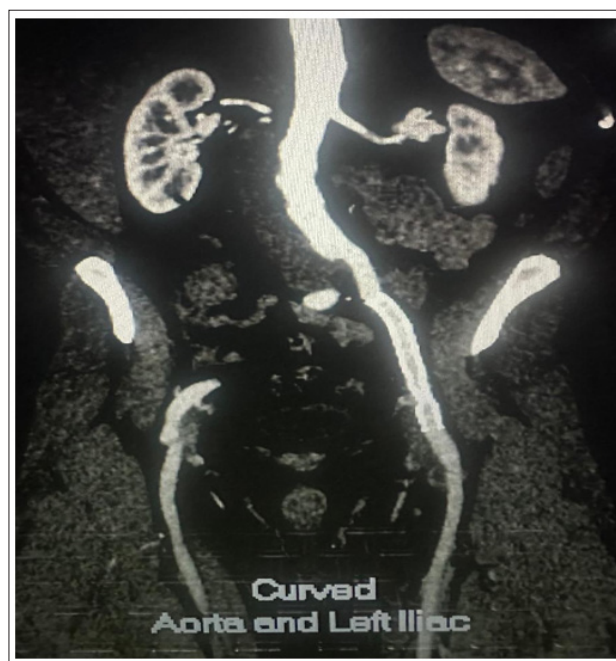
CT-SCAN After 3 Years and 11 Months Follow-Up Demonstrating Wrapsody Patency
